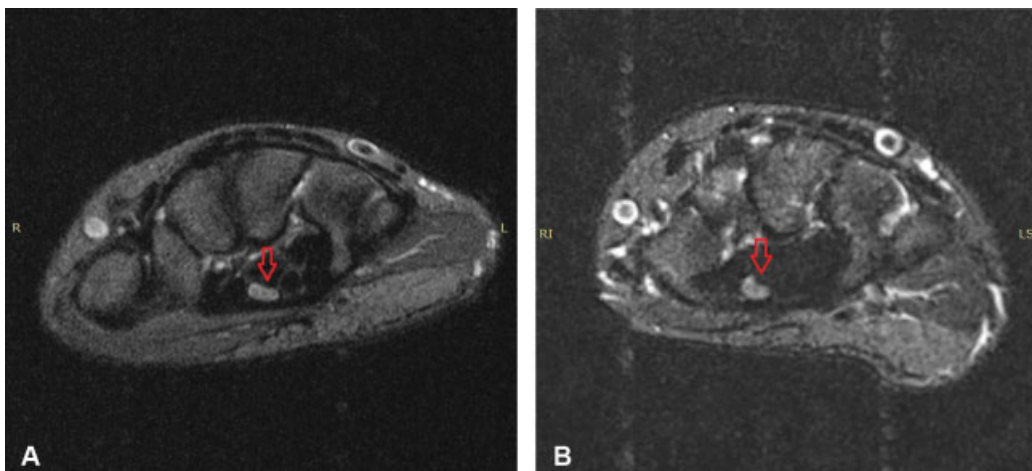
Medial nerve: dedicated extremity MRI (A) versus conventional MRI (B).
